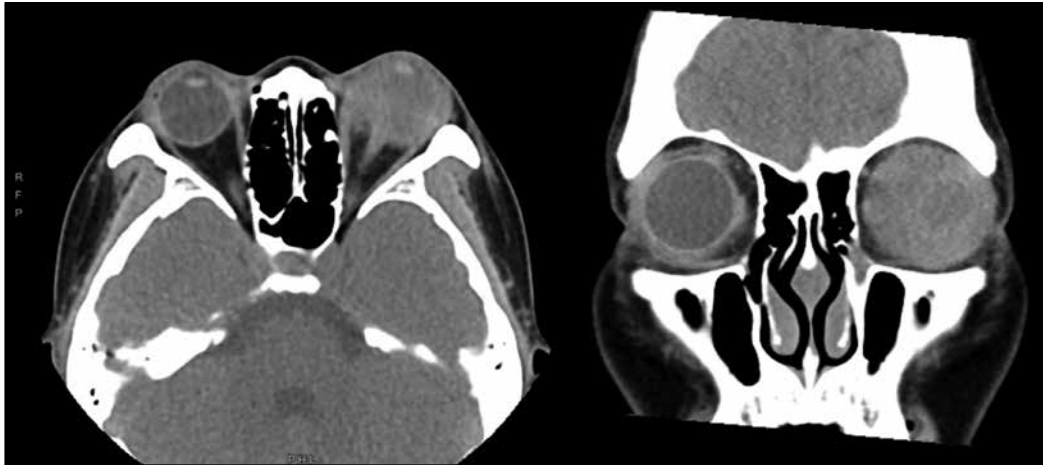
Computed tomography of the orbits showing progressive enlargement of the left eye intraocular mass filling and expanding the globe and causing left eye proptosis.
